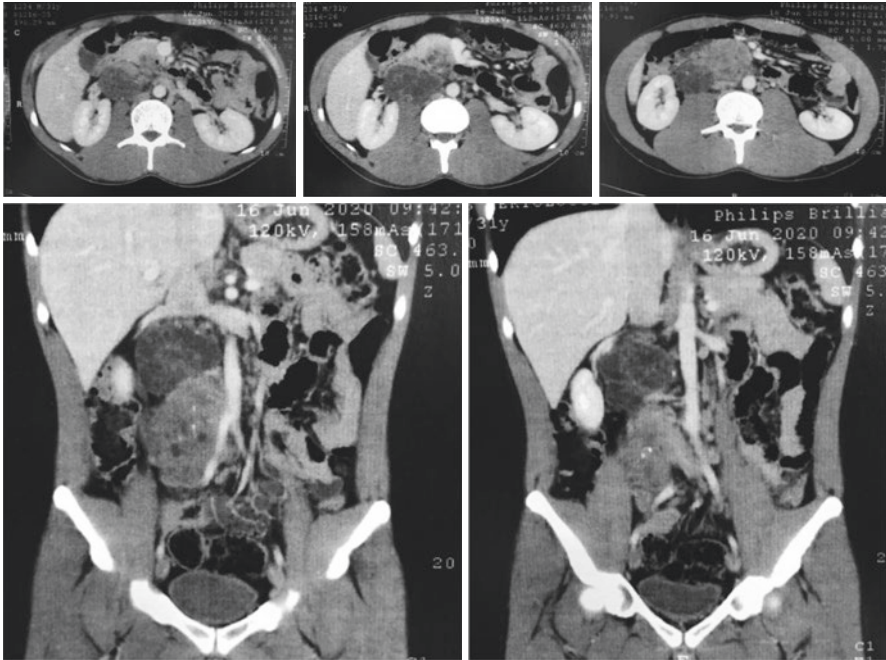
A 31-year-old male patient who sought medical attention complaining of low back pain on the right. The images showed a large retroperitoneal mass, predominantly solid with areas of necrosis and involvement of the right common, the common iliac artery and the right renal pedicle. The inferior vena cava also seems to be involved. The patient did not report testicular changes, however, as part of the investigation; AFP and HCG- β were collected and proved to be increased. The testicular ultrasound performed in the sequence revealed a 6 mm lesion in the right testicle. The patient underwent radical orchiectomy, and the pathological examination confirmed the presence of a small area of embryonic carcinoma. The patient was treated according to a systemic chemotherapy protocol, with normalization of the markers, but with persistence of a large residual retroperitoneal mass. He is currently scheduled for surgery with the possibility of associated vascular resection
